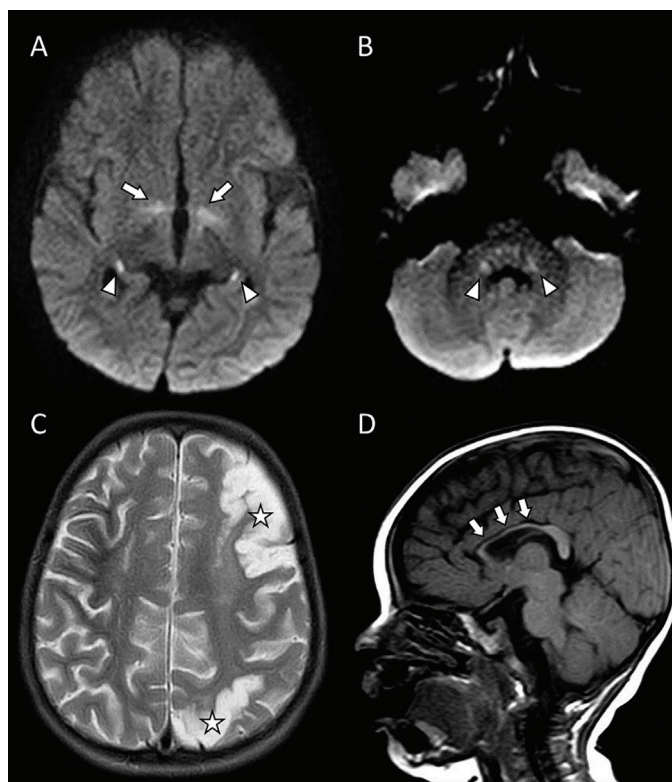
Examples of MRI findings accompanying CTTH. A) Bilateral signal increase in the posterior crus of the fornix-hippocampus (arrowheads) and hypothalamus (arrows) on diffusion MRI, B) Symmetrical signal increase in the inferior cerebellar peduncles (arrowheads) on diffusion MRI, C) Areas of gliotic encephalomalacia (stars) secondary to an old left frontoparietal infarct in a case of cerebral palsy on T2W imaging, and D) Thinning of the genu and body of the corpus callosum (arrows) on sagittal T1W imaging
